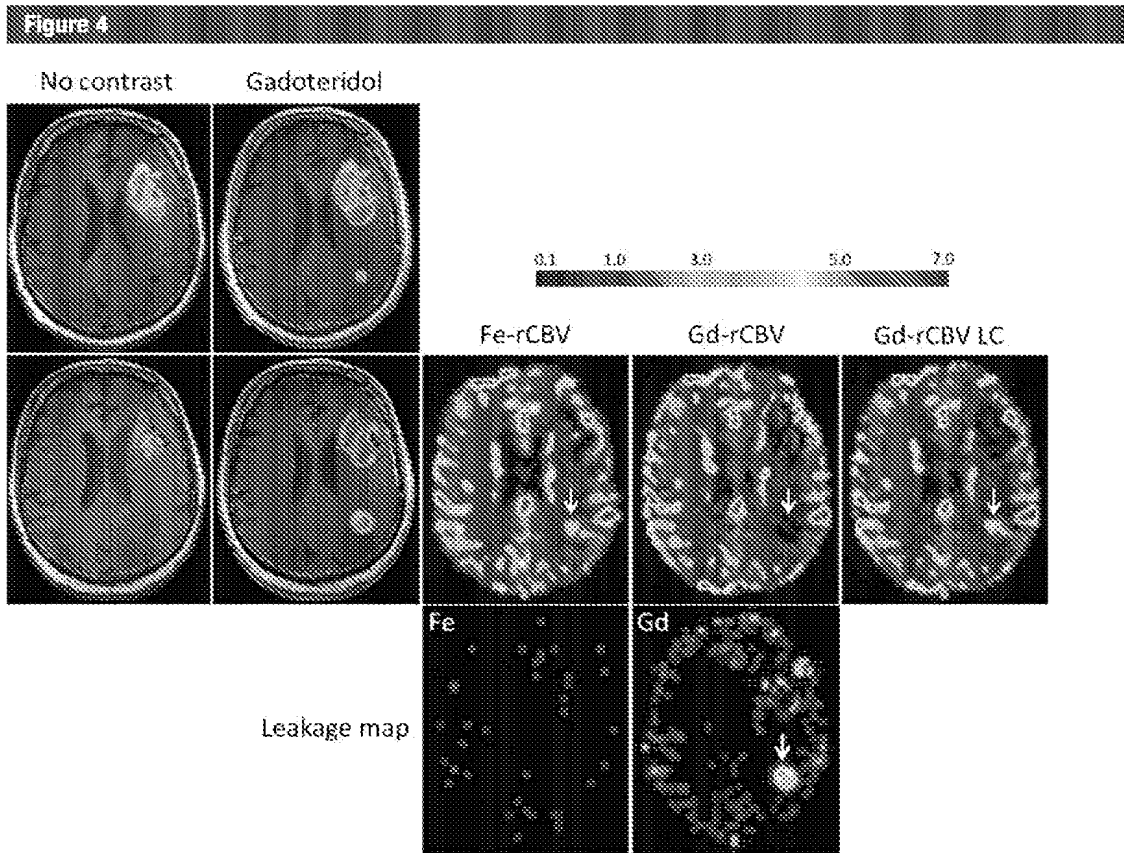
Axial images of 59-year-old woman with GBM show progression of disease. T1-weighted MR images without contrast agent and with gadoteridol (*Gd*) obtained before and 2 weeks after chemoradiotherapy (*CRT*) show increased contrast enhancement after treatment. High rCBV ( $> 1.75$ ) is apparent on parametric maps obtained by using ferumoxytol (*Fe-rCBV*), gadoteridol (*Gd-rCBV*), and gadoteridol with leakage correction (*Gd-rCBV LC*), which indicates true tumor progression (arrows). No contrast agent extravasation is seen on leakage map with ferumoxytol (*Fe*) but small leakage in the lateral aspect of the tumor is seen with gadoteridol.
